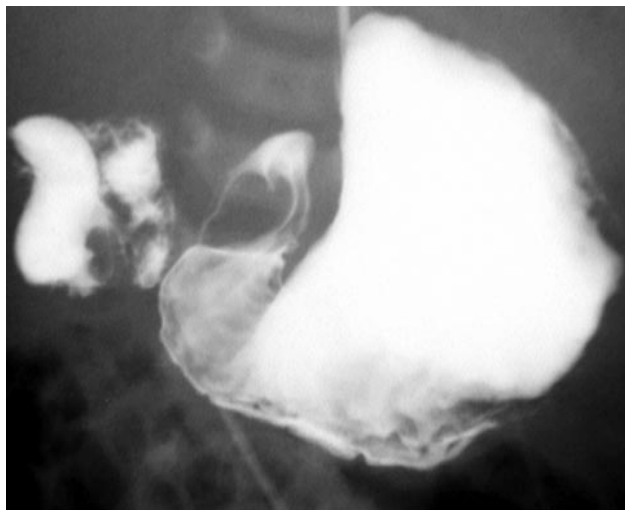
Malrotation with obstructing duodenal bands in a neonate. Radiograph shows distention of the proximal part of the duodenum by barium, but no air or barium in the distal part. In this situation, it may be impossible to distinguish duodenal atresia from malrotation and volvulus. The imaging findings therefore should be discussed with the referring physician and correlated with the clinical manifestations.
